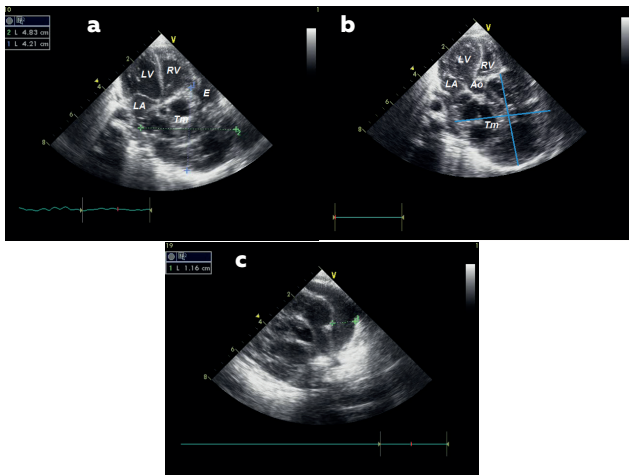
Echocardiographic apical four and five-chambers views (a+b) demonstrating a heterogeneous mass (arrow) with multiple hypolucent cystic areas compressing the right atrium, with mild pericardial effusion. The tumor mass measures 4.8 cm × 4.2 cm. Short axis view (c) mild pericardial effusion regarding the unfundibular tract.
